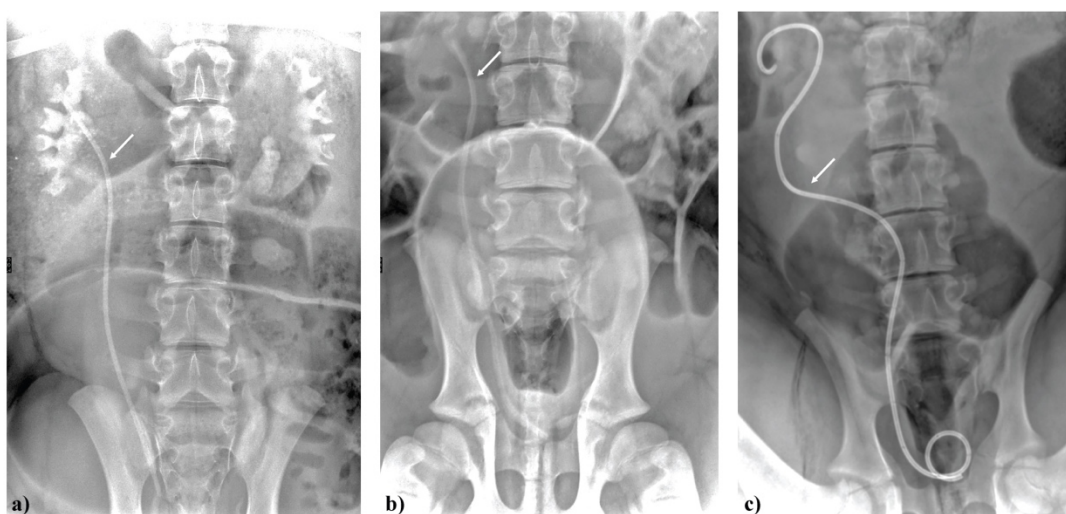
2 X-ray image of biodegradable ureteral stent at a) day 0 and b) day 1. c) Commercial ureteral stent at day 1.
